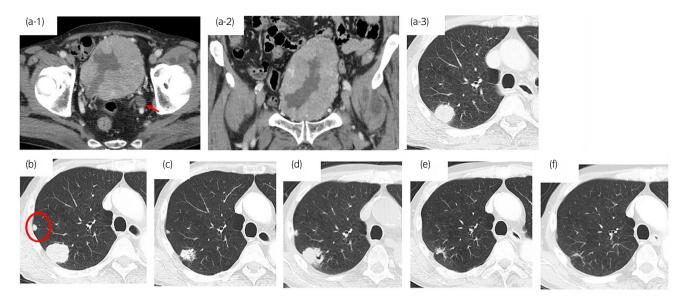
(a) CT findings at the first visit, a-1) horizontal view of bladder cancer and left hydroureter (red arrow); a-2) coronal view of bladder cancer; a-3) horizontal view of single lung metastasis. (b) CT findings just before first-line GC chemotherapy, showing the enlarged main lung metastatic lesion as well as a new small lesion (red circle). (c) CT findings after four cycles of GC chemotherapy, showing the reduction of metastatic tumor size. The final response was determined as a stable disease. (d) CT findings after third administration of avelumab maintenance therapy, showing the increased size of lung metastases. (e) CT findings after seventh dose of avelumab administration show a dramatic reduction in main lung metastatic tumor size and a small lesion of another lung metastasis, which almost disappeared. (f) CT findings 8 months after the resumption of avelumab administration therapy show no regrowth of lung metastatic tumor.
